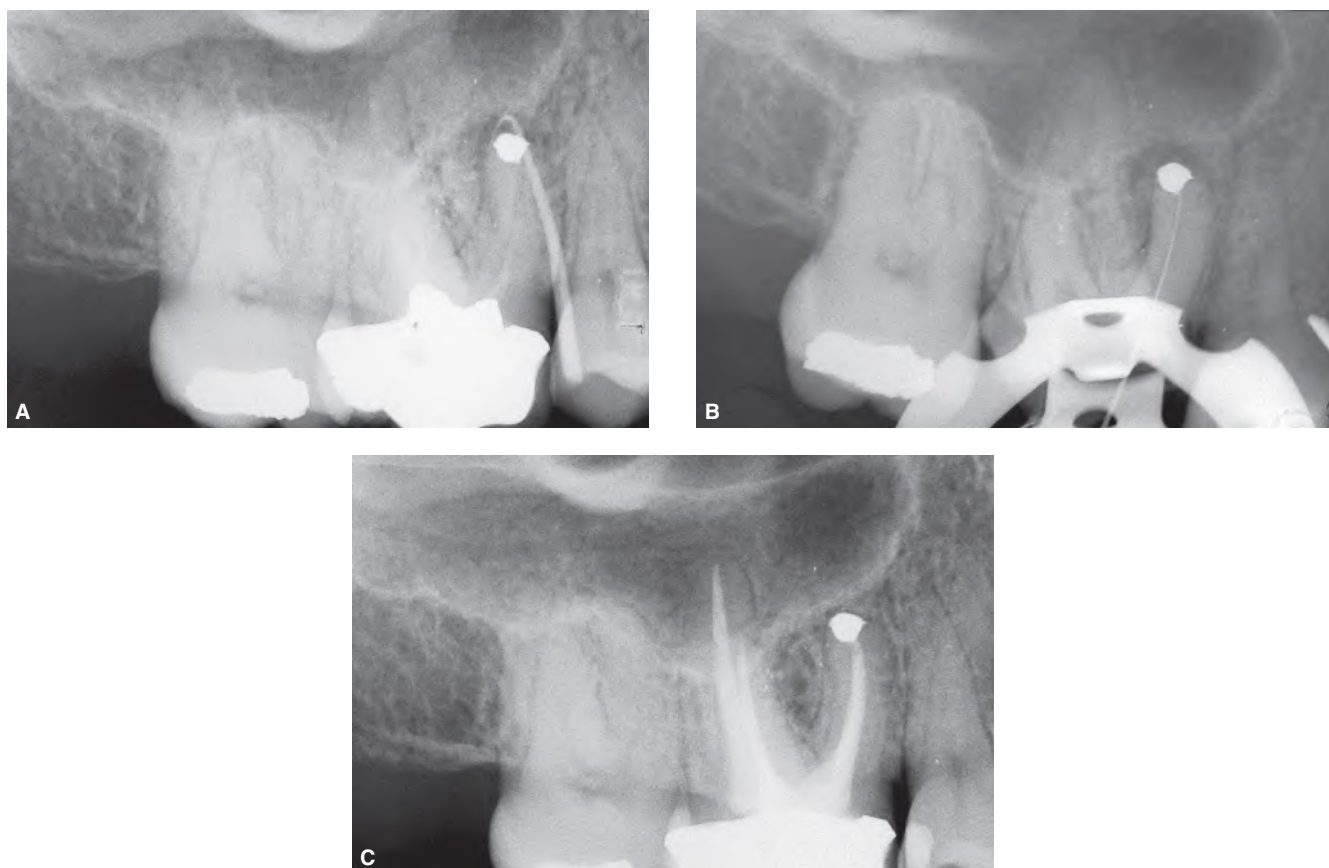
Nonsurgical retreatment of a failed endodontic surgery. A. Preoperative radiograph of a maxillary right first molar. Gutta-percha cone indicates the presence of a sinus tract. B. Intraoperative radiograph. The obturation of the MB-1 and MB-2 canals was done using thermoplastic gutta-percha. The previous amalgam root-end filling served as apical stop. Careful execution will not push filling material to the periapical tissues. C. Two-year recall radiograph showing therapy has been successful.
